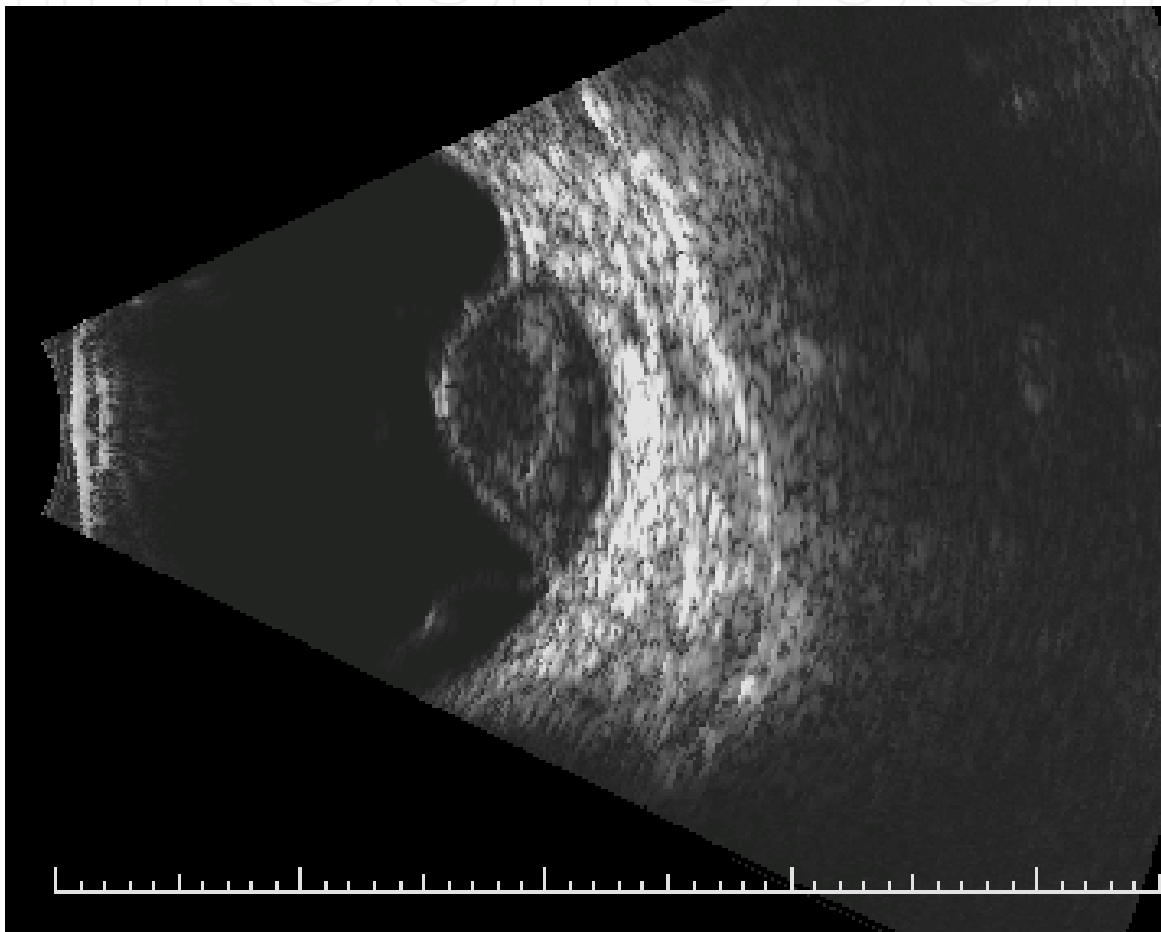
B-scan ultrasound of the tumor in Figure 2A at diagnosis with an apical height of 7.5 mm.
